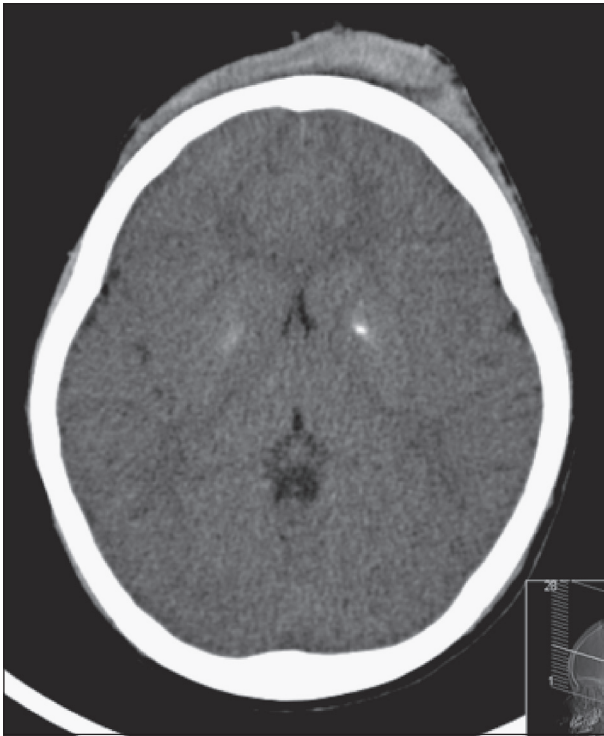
CT (axial plane), without contrast, revealing bilateral spot calcification in the basal ganglia.
